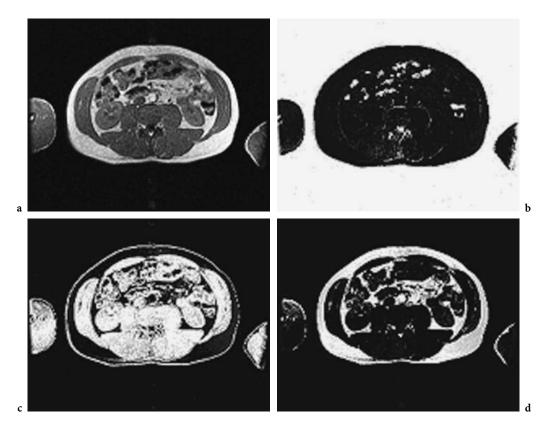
Segmentation of MRI abdominal images by the fuzzy C-mean clustering algorithm. Original image (a), background signal map (b), muscle tissue map (c) and fat map (d)
